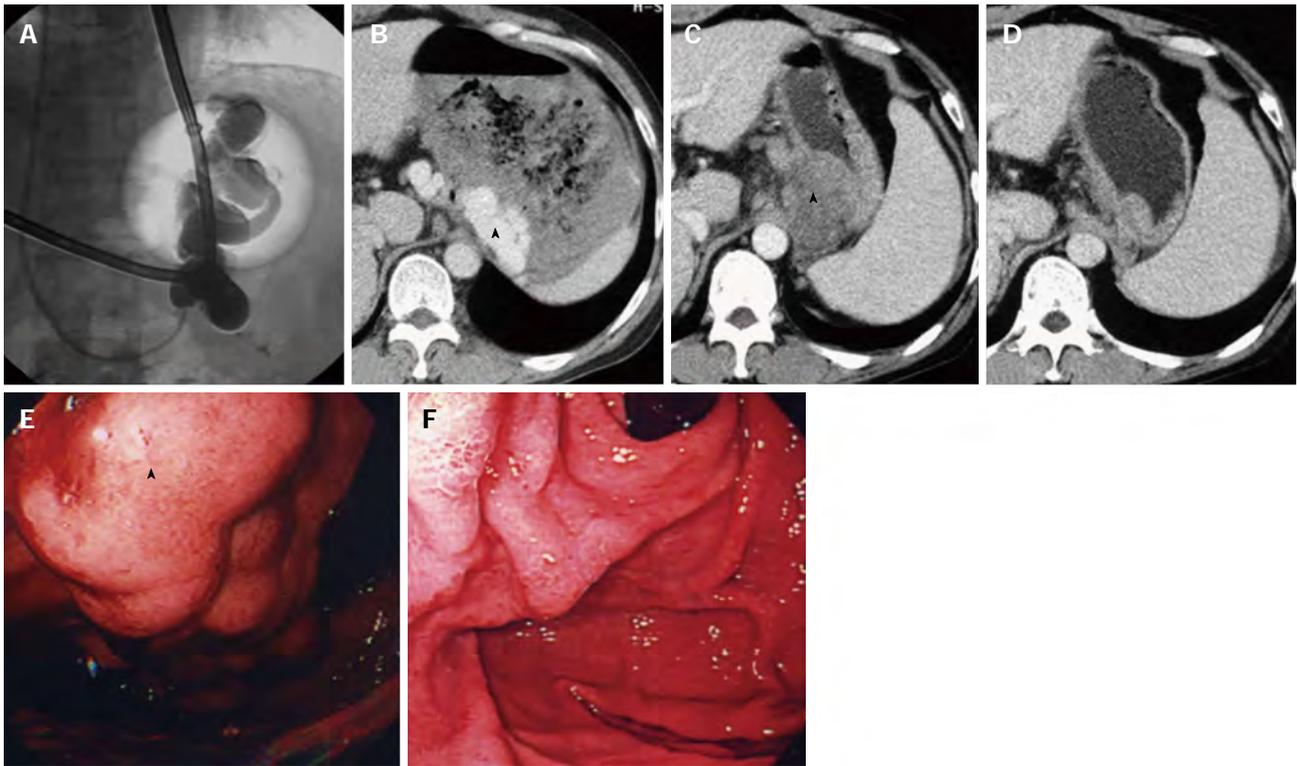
Gastric varices with a gastrorenal shunt (case 15). A: Balloon-occluded retrograde transvenous obliteration (BRTO) was performed 11 h after hematemesis. The gastric varices and a gastrorenal shunt were filled with 36 mL of 5% ethanolamine oleate iopamidol. A Sengstaken–Blakemore tube was inserted into the stomach for temporary hemostasis; B: Contrast-enhanced computed tomography (CE-CT) image taken before BRTO shows gastric varices (arrowhead) with a massive hematoma; C: CE-CT image taken 1 wk after BRTO shows complete thrombosis of the varices (arrowhead); D: CE-CT image taken 6 mo after BRTO shows complete disappearance of the varices; E: Endoscopy performed before BRTO shows gastric varices (arrowhead) with oozing; F: Endoscopy performed 6 mo after BRTO shows complete disappearance of the varices.
